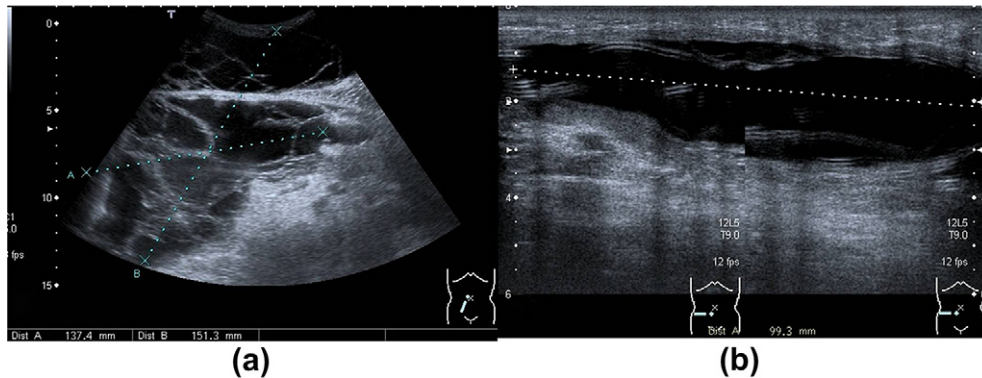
(a) Ultrasound appearances of a lymphocoele seen in a patient following renal transplant and (b) anechoic appearance of a seroma in a different patient following surgery for excision of sarcoma.
